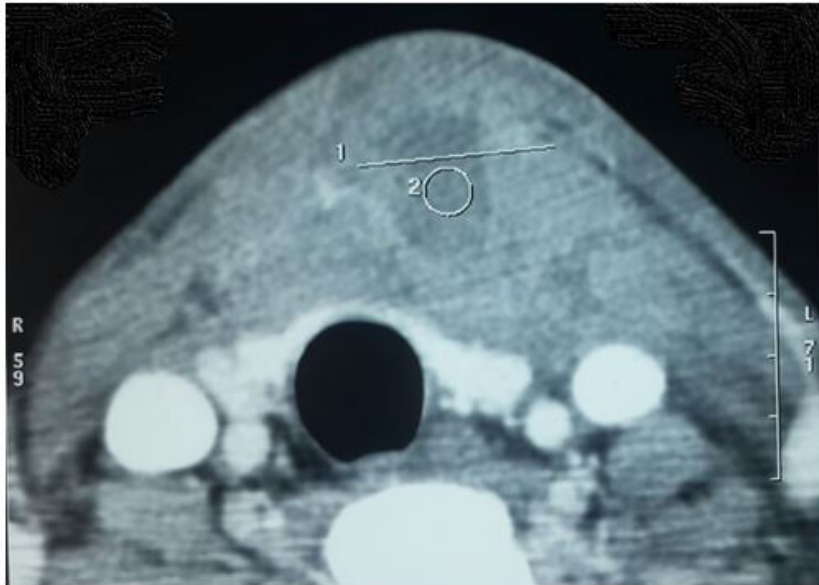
Cervical computed tomography
